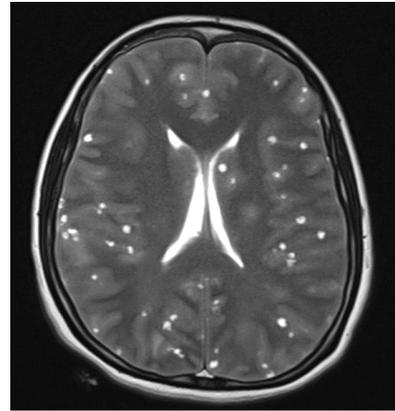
MRI T2WI at the ventricular level
